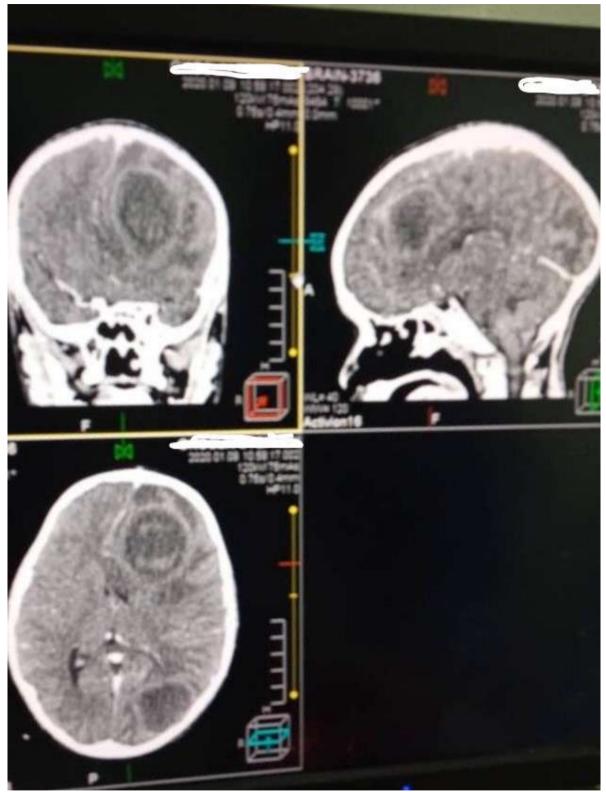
Contrast-enhanced cranial CT (coronal, sagittal and axial sections) showing multiple hypodense lesions of varying sizes with thin uniform ring-like enhancement and perilesionaloedema in the left frontoparietal and occipitalregions.
